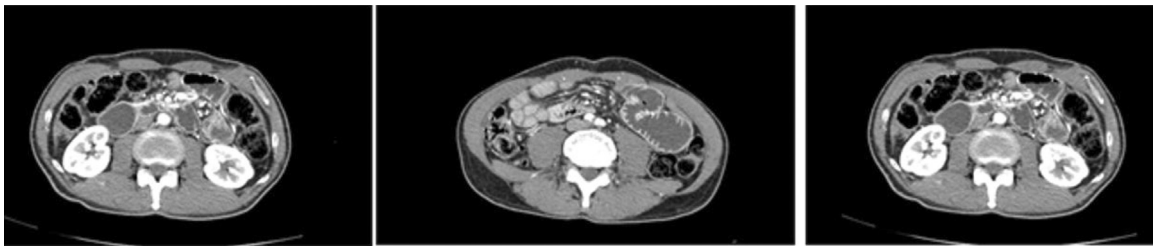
A contrast-enhanced CT abdominal scan revealed some air-fluid levels in the center of the abdomen with distension of some proximal jejunal loops.
